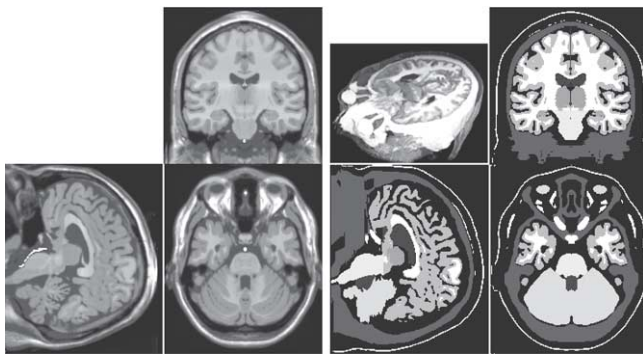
Atlas purpose-built for radiotherapy. (Left) Symmetrical artificial magnetic resonance imaging (MRI) (data from BrainWeb); basilar artery was added to avoid matching this structure with the brainstem. (Right) Result of the segmentation of the artificial MRI and the three-dimensional view. Main organs at risk are: eyes, optic nerve, optic chiasm and optic tract, pituitary gland, brainstem, and basal ganglia (thalamus, caudate ganglia, putamen, and pallidum). Fat, skull, and skin are segmented for radiotherapy purposes.
